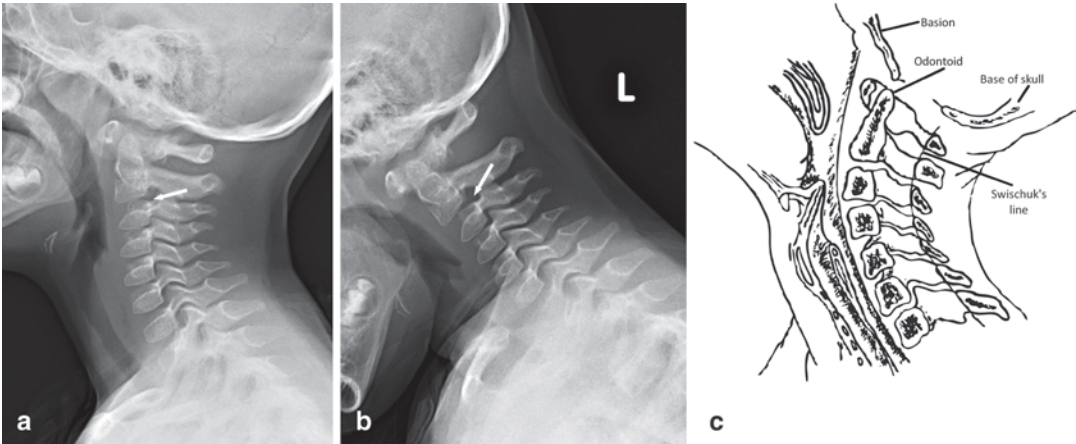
Pseudosubluxation. Appearance of pseudosubluxation (*arrows*) on lateral radiograph in both a neutral and b flexion. A normal physiologic listhesis can be seen in the c-spine of children, with C2–3 the most common location. This is typically less than 2–3 mm. Further, note the disproportionate increase in distance with flexion between the C1 and C2 spinous processes. c The spinolaminar line (Swischuk's line) can be used to differentiate pseudosubluxation from true injury
